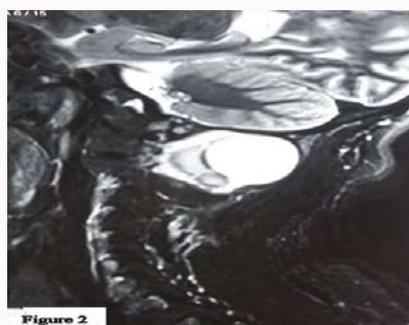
MRI (T2 sagittal)-Cyst shows high signal on T2 weighted image.
